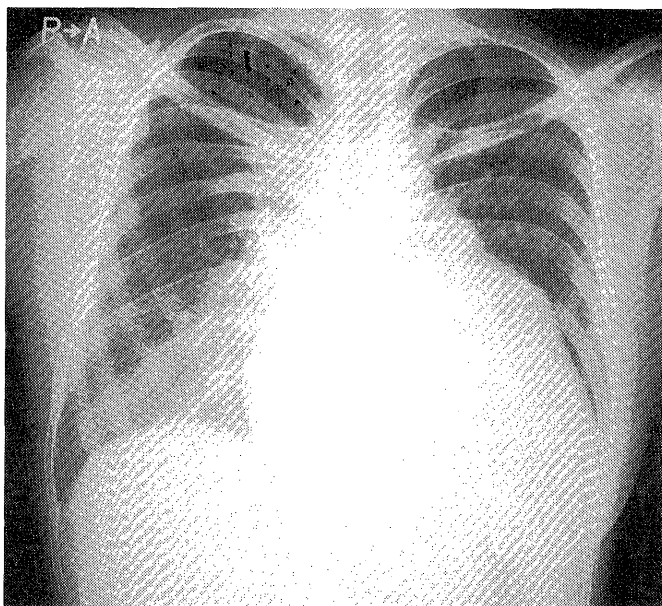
Chest x-ray on admission showing cardiomegaly with dilatation of the left atrium.
